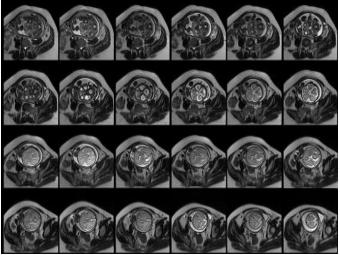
A volume of Fetal MRI of abnormal brain (GW 29)
